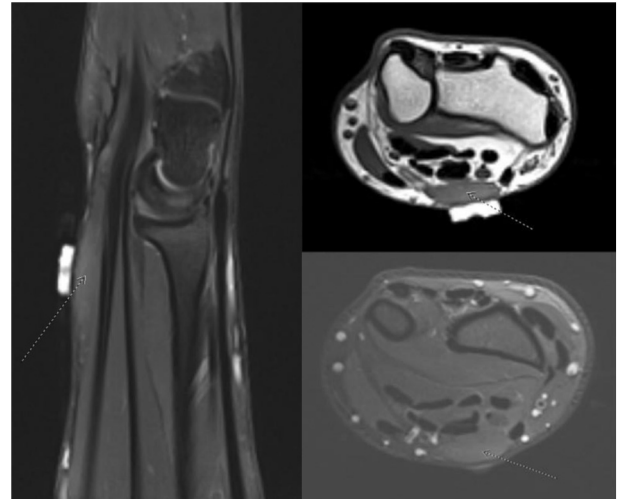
Sagittal and coronal magnetic resonance images demonstrating the muscle belly of the reversed palmaris longus (white arrows).
